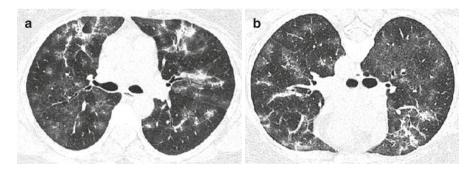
(a) HRCT scan of the lungs in supination with an image of fine regions of GGO. In addition, ventrally there are fine fibrous changes. (b) The same patient, the same layer, only with the patient rotated on the abdomen. It is clear that the previous image-density changes persist in the pulmonary parenchyma
